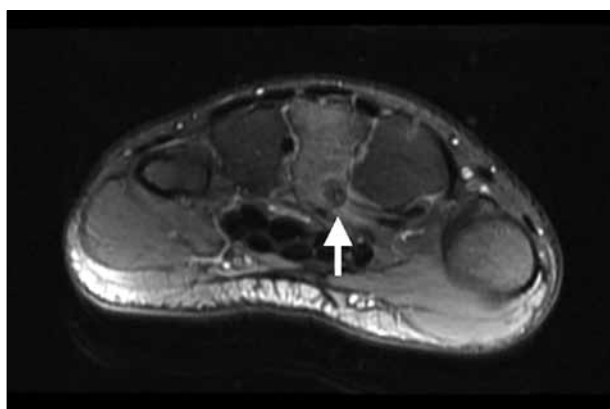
Magnetic resonance imaging of the second patient
